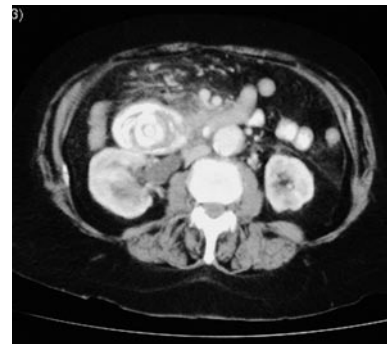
CT abdomen with contrast showing the gall stone in the duodenum with some contrast passing distal to the stone.
